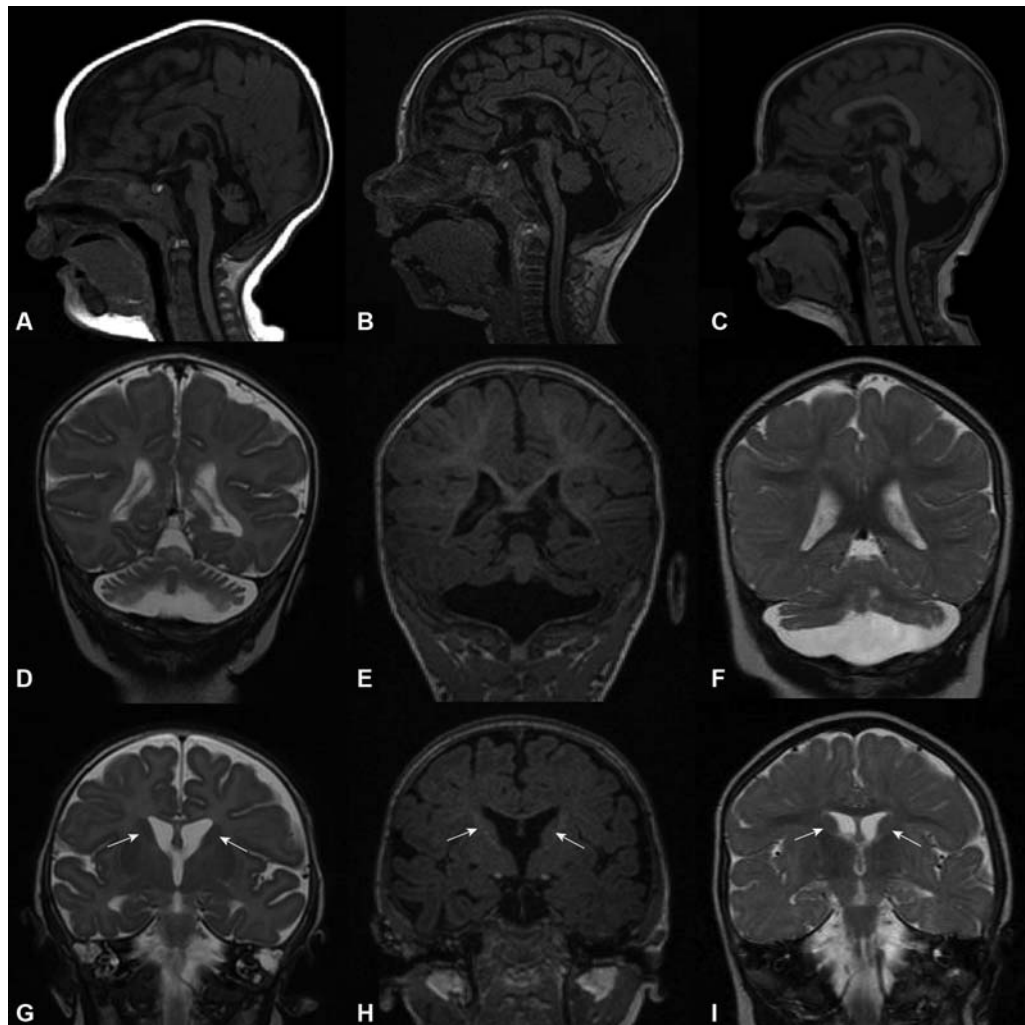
MRIs (magnetic resonance imagings) of patients with pontocerebellar hypoplasia (PCH (1B), PCH2A, and microcephaly and PCH (MICPCH). (A–C) Midsagittal T1-weighted images of a patient with PCH1B, PCH2A, and MICPCH, respectively. Note loss of volume of the ventral pons and severe vermal hypoplasia in all three cases. (D–I) Coronal sections of PCH1B (D,G), PCH2A (E,H), and MICPCH (F,I) patients. Note relative sparing of the cerebellar vermis compared with the cerebellar hemispheres and flattening of the head of the caudate nucleus in PCH1B and PCH2A, but not in MICPCH. The caudate nucleus is indicated with a yellow arrow.
